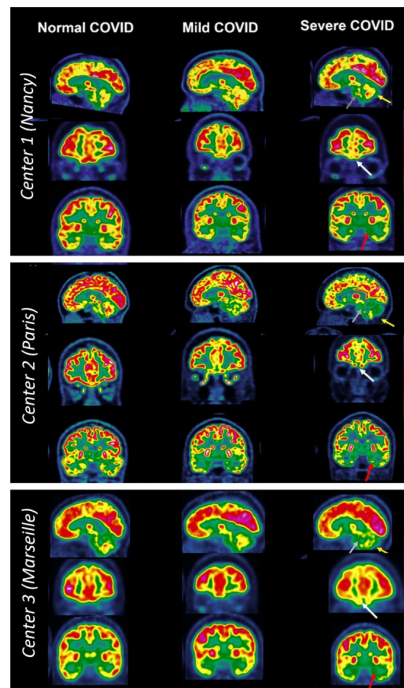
18F-FDG PET images of nine patients with long COVID. Republished with permission from Antoine Verger *et al.*
